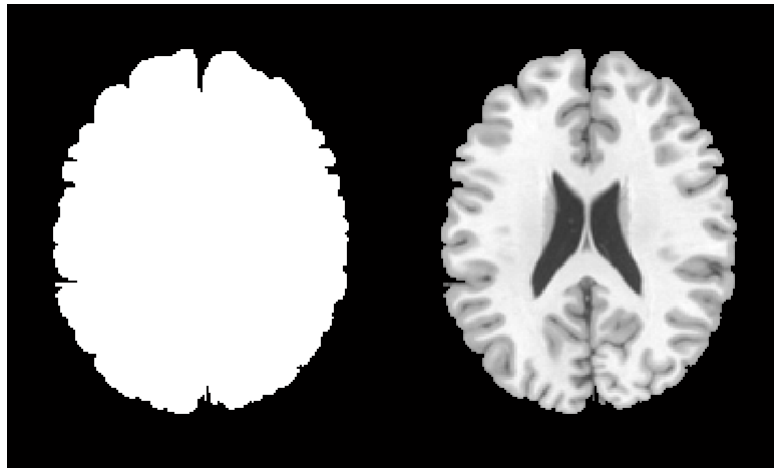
On the left there is an example of binary mask generated with the command 'bet'. On the right the brain extracted with the binary mask from a MRI.
